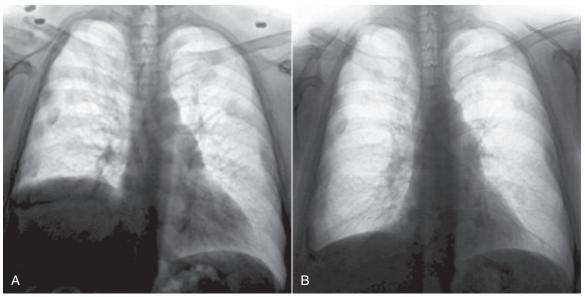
(A) Chest X-ray showing elevation of a right hemidiaphragm. (B) Chest X-ray in the same patient 1 year after laparoscopic diaphragm plication. (From Groth SS, Andrade RS: Diaphragm plication for eventration or paralysis: a review of the literature, *Ann Thorac Surg* 89:S2146–S2150, 2010.)
